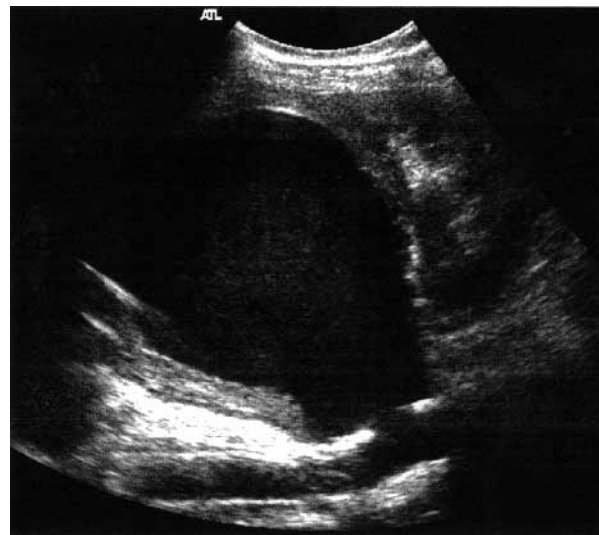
Ultrasound scanning cross section of left lower abdominal quadrant with 5-MHz sector tracer showing false aneurysm that is 10 cm in diameter at distal anastomosis of thoracoabdominal Dacron bypass graft.
